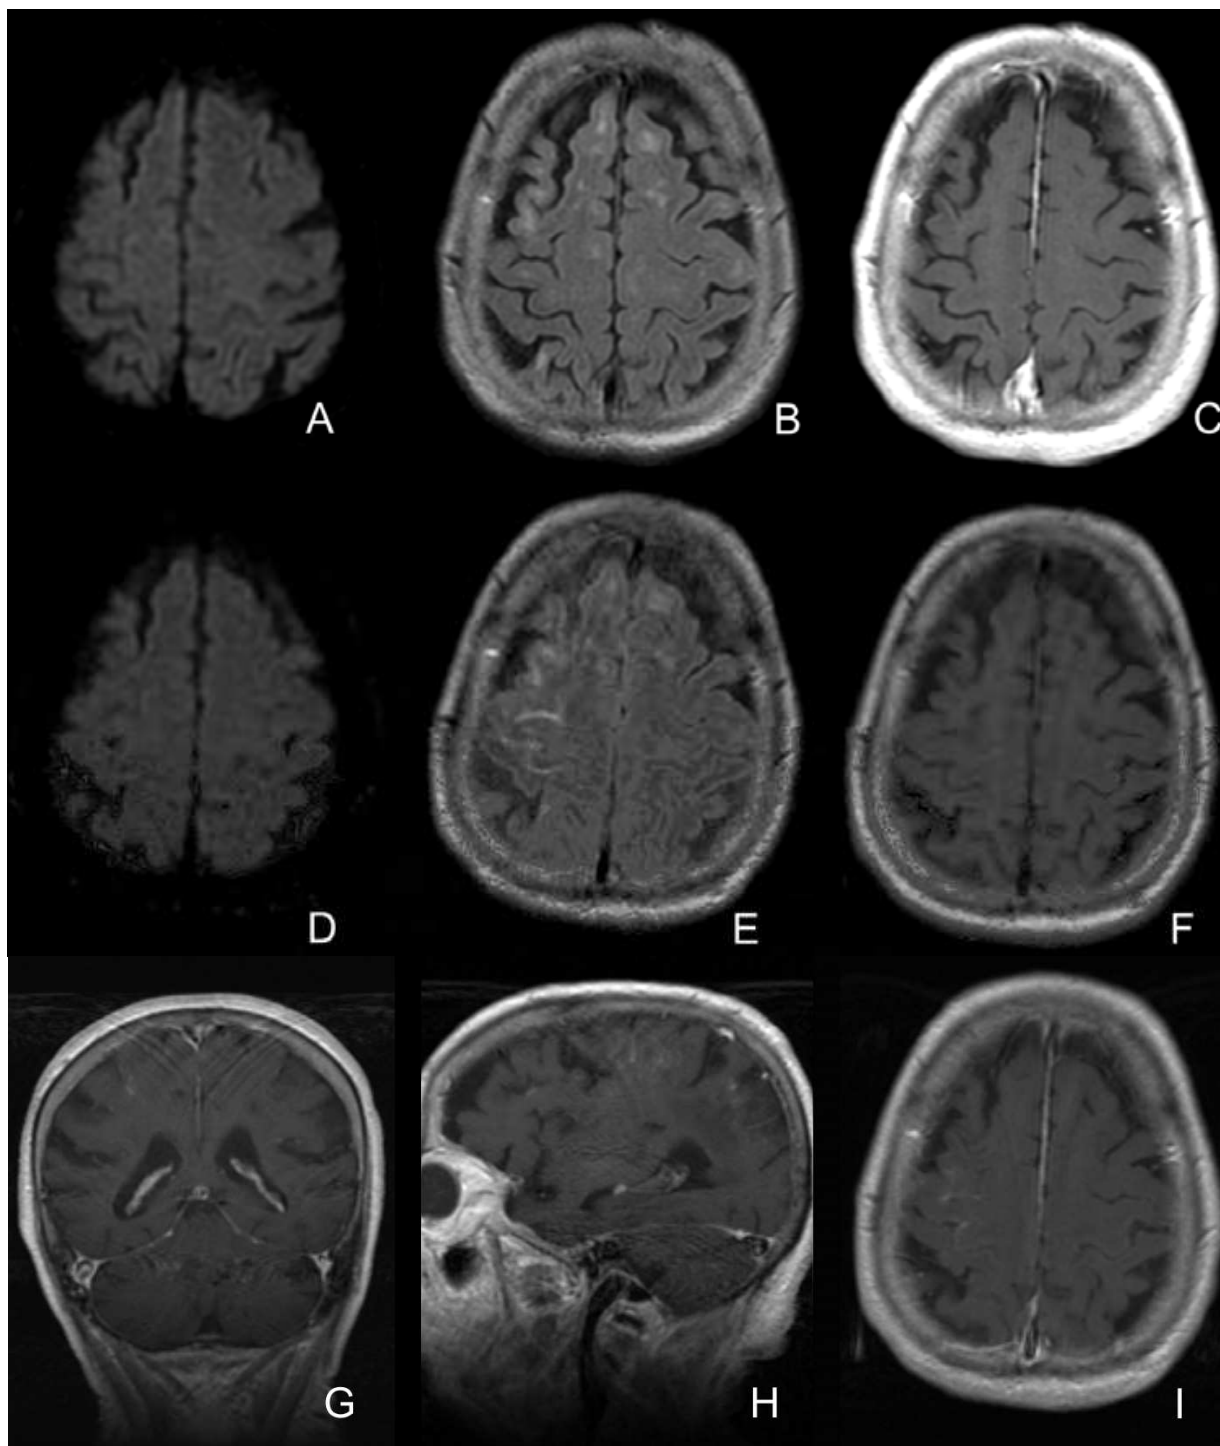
An 87-year-old patient with right carotid artery stenosis. MRI in diffusion sequence before CAS: DWI (A), FLAIR (B) and T1 with gadolinium (C). Conventional angioplasty of the carotid artery was performed (not shown), and the patient was asymptomatic after endovascular treatment. A new MRI study was performed 12 hours after CAS (D,E,F,G,H,I): note the hypersignal in the central and precentral sulcus of the FLAIR sequence (E) without expression in DWI (D) or T1 without gadolinium (F). T1 sequences with coronal (G), sagittal (H) and axial (I) contrast after CAS: enhancement in the sulcal (pial) space in the right posterior frontal area.
